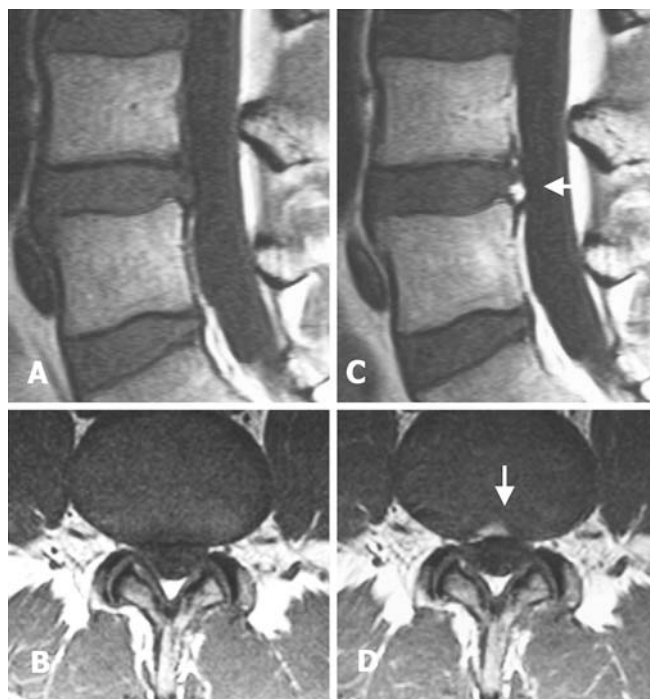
Selection of intervertebral disc for intradiscal injection. A, B Sagittal and axial T1-weighted MR images. C, D Sagittal and axial Gd-DTPA enhanced T1-weighted MR images. The intervertebral disc containing an obvious enhanced region in its posterior annulus on Gd-DTPA enhanced T1-weighted MR images was selected for intradiscal injection (arrows). When an enhanced region was detected in many discs, the disc with the widest and most intense enhanced region was selected. When no enhanced region was detected, the most severely degenerated disc on T2-weighted MR images was selected.
